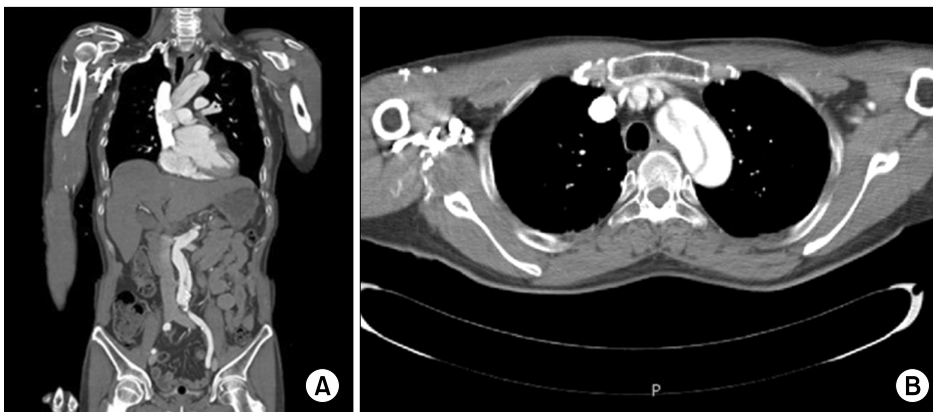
A Stanford type A aortic dissection documented on (A) a coronal and (B) an axial chest computed tomography scan.
